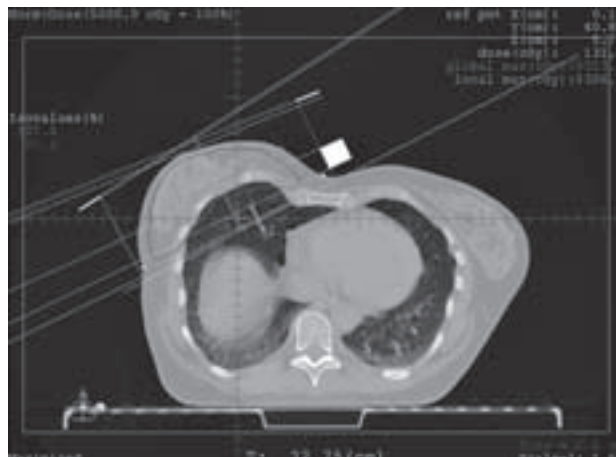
CT slice showing isodose curves
